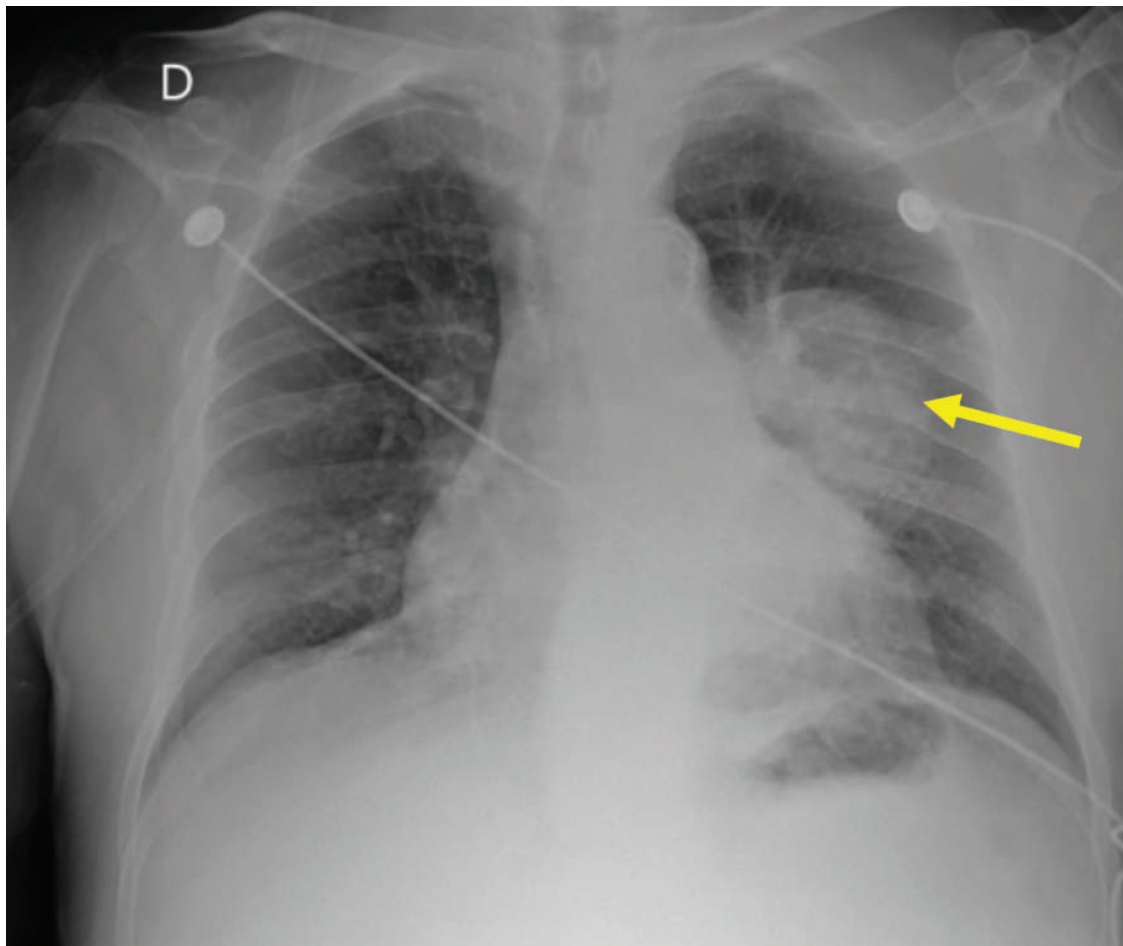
Frontal chest X-ray.
